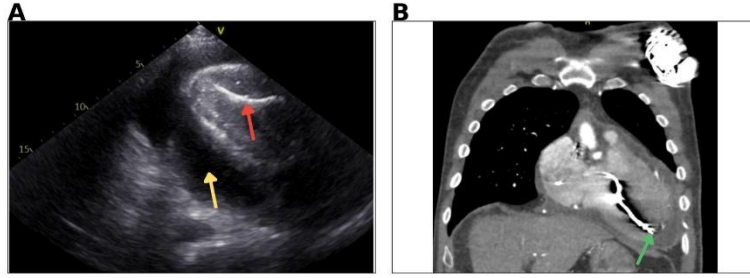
Multimodality imaging of late right ventricular defibrillator lead perforation. A: Transthoracic echocardiography showing massive pericardial effusion (yellow arrow) and the defibrillator lead in contact with the right ventricular myocardium (red arrow). B: Chest computed tomography confirming right ventricular apical lead perforation, with the lead tip extending beyond the myocardial contour (green arrow).
